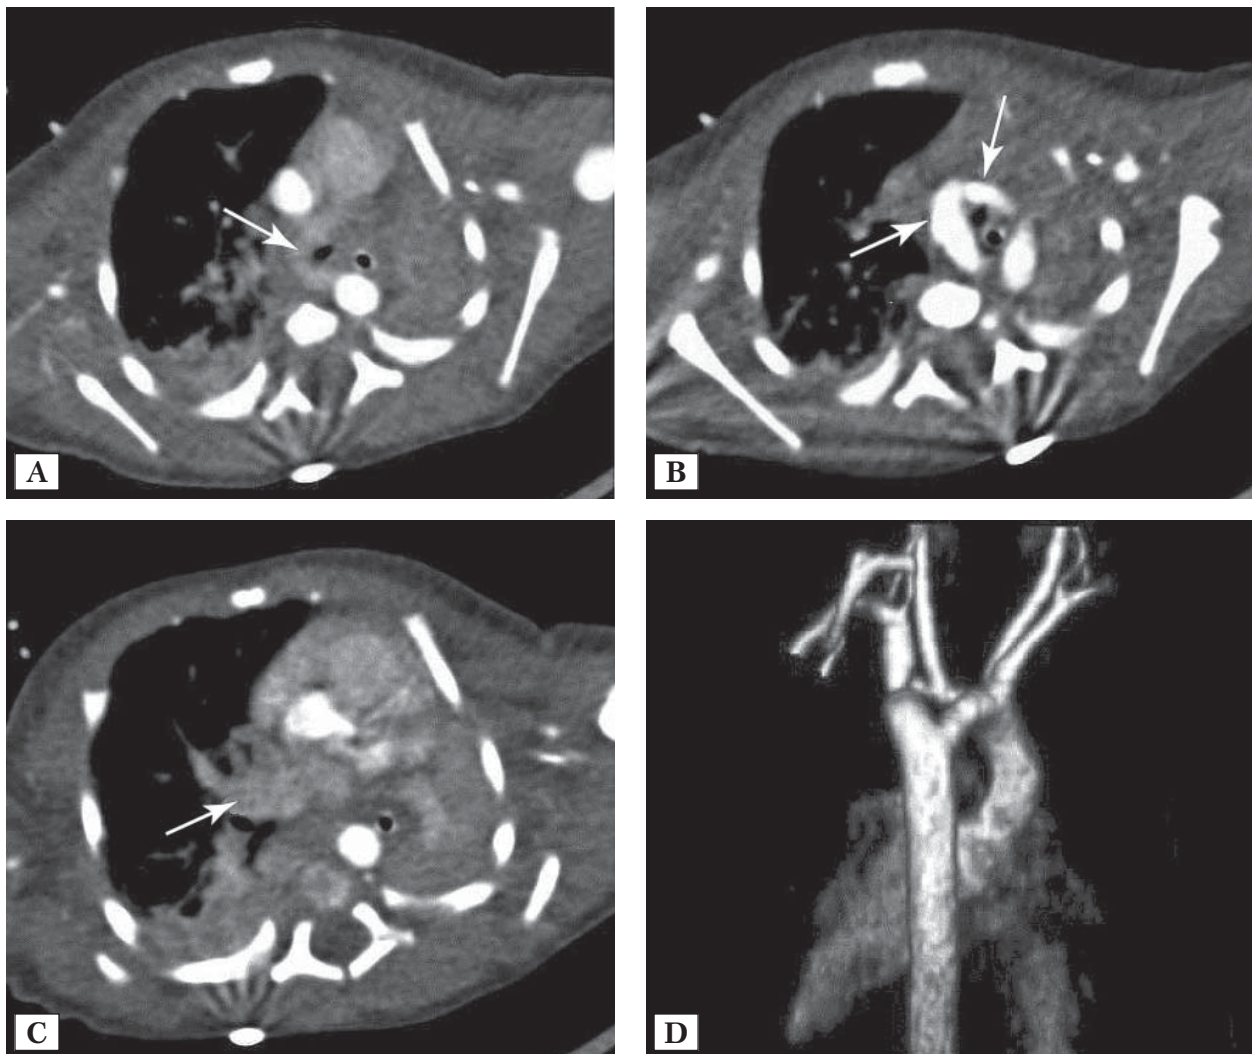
Multispiral contrast enhanced chest CT in a newborn boy R., with double vascular ring, total anomalous pulmonary venous drainage and tracheal stenosis. A – Axial scan: left PA forms the sling around distal trachea (arrow), atelectasis of the left lung. B – Double aortic arch with both arches patent and dominating right arch (arrows). C – Venous collector that drains into the right atrium (arrow). D – 3D reconstruction demonstrating double aortic arch and separate brachiocephalic vessels (posterior view)
